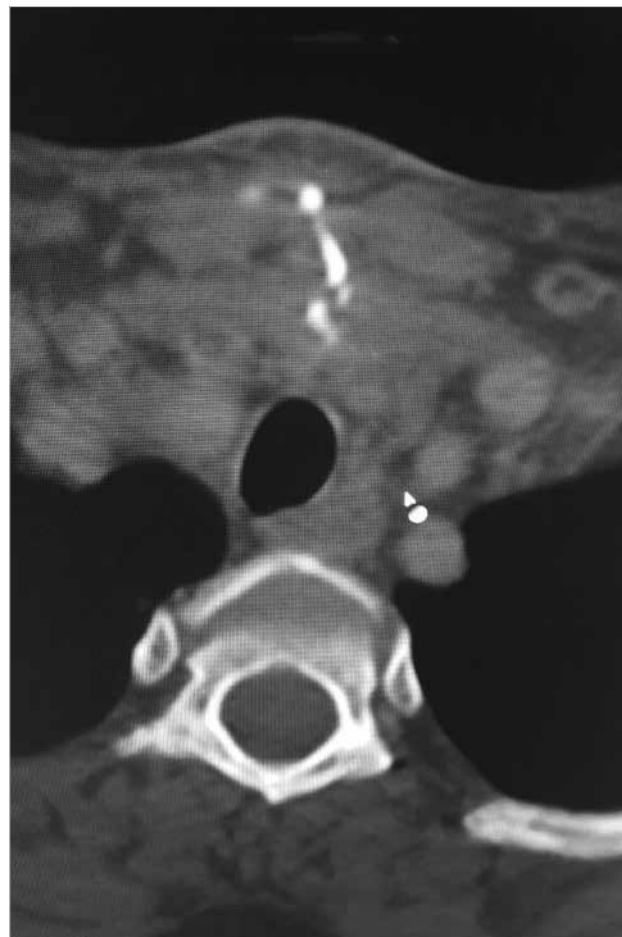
CT view of the fistula tracts extending from the incision line to the trachea
